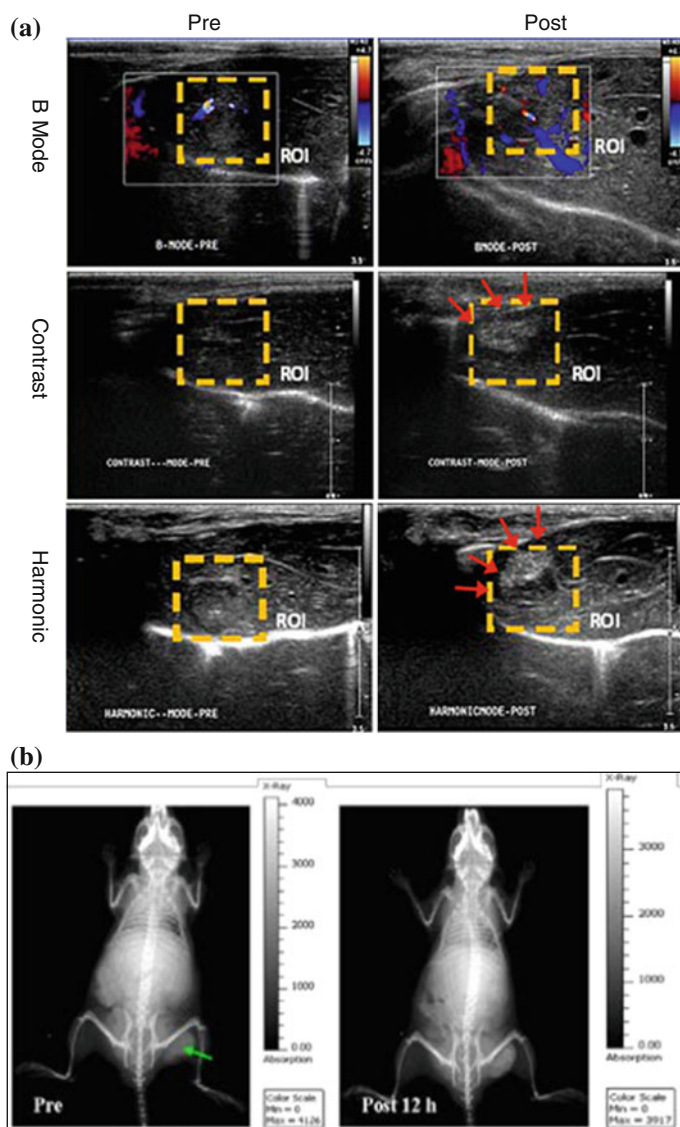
a Ultrasound imaging in rabbit VX2 liver tumor before and after the injection of perfluorohexane-encapsulated MSNs. b In vivo planar X-ray images before and 12 h after the injection of ICG-loaded Au@MSN. Recreated with kind permission from Elsevier B. V. [98] and OSA [100]
